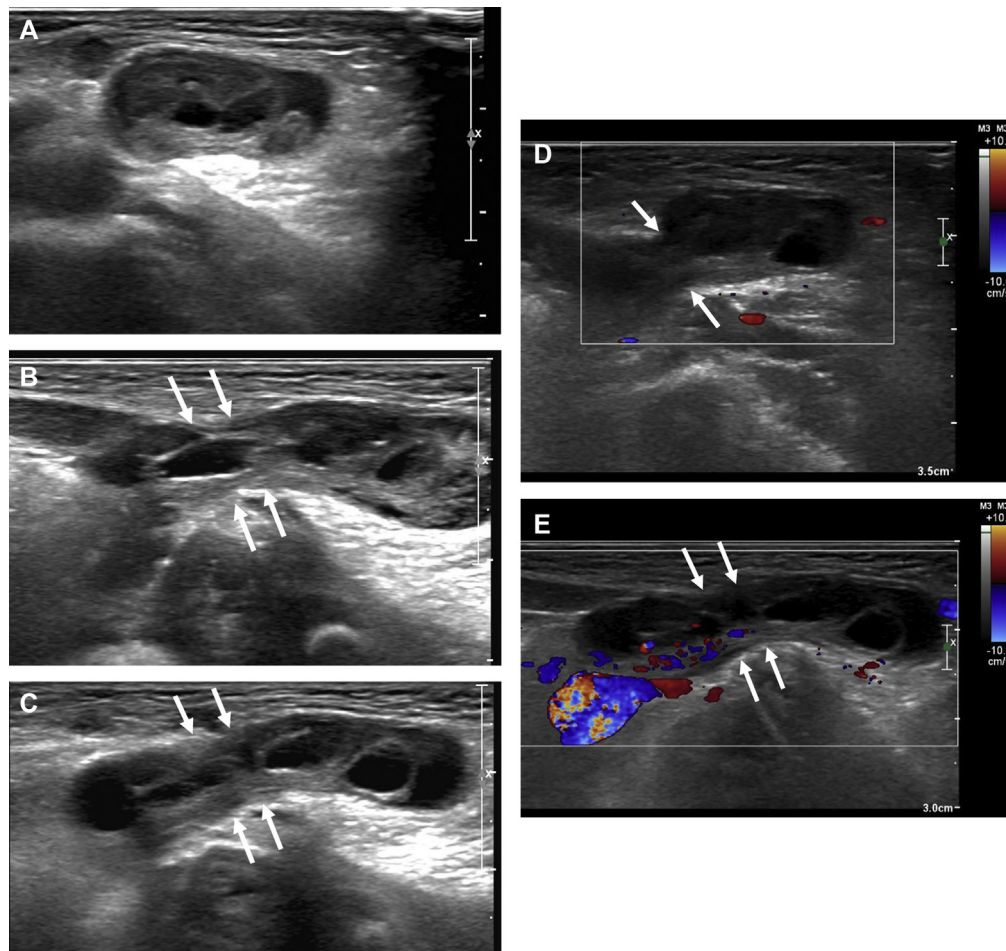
A 15-day-old female infant presented with palpable mass in the right inguinal region. A–C. Transverse (A) and longitudinal (B, C) gray scale ultrasound (US) reveals a well-circumscribed, oval, hypoechoic solid mass with internal small cysts in the right inguinal area, and there is no evidence of peristalsis or fat within the mass. And the lesion extends to the abdominal cavity through the canal of Nuck (arrows). These sonographic findings suggest that the herniated content is the right ovary. D, E. On color Doppler US, blood flow is seen at the canal of Nuck, representing ovarian vessel. However, no blood flow was seen within the mass. This finding strongly suggests a strangulation of the ovary.
